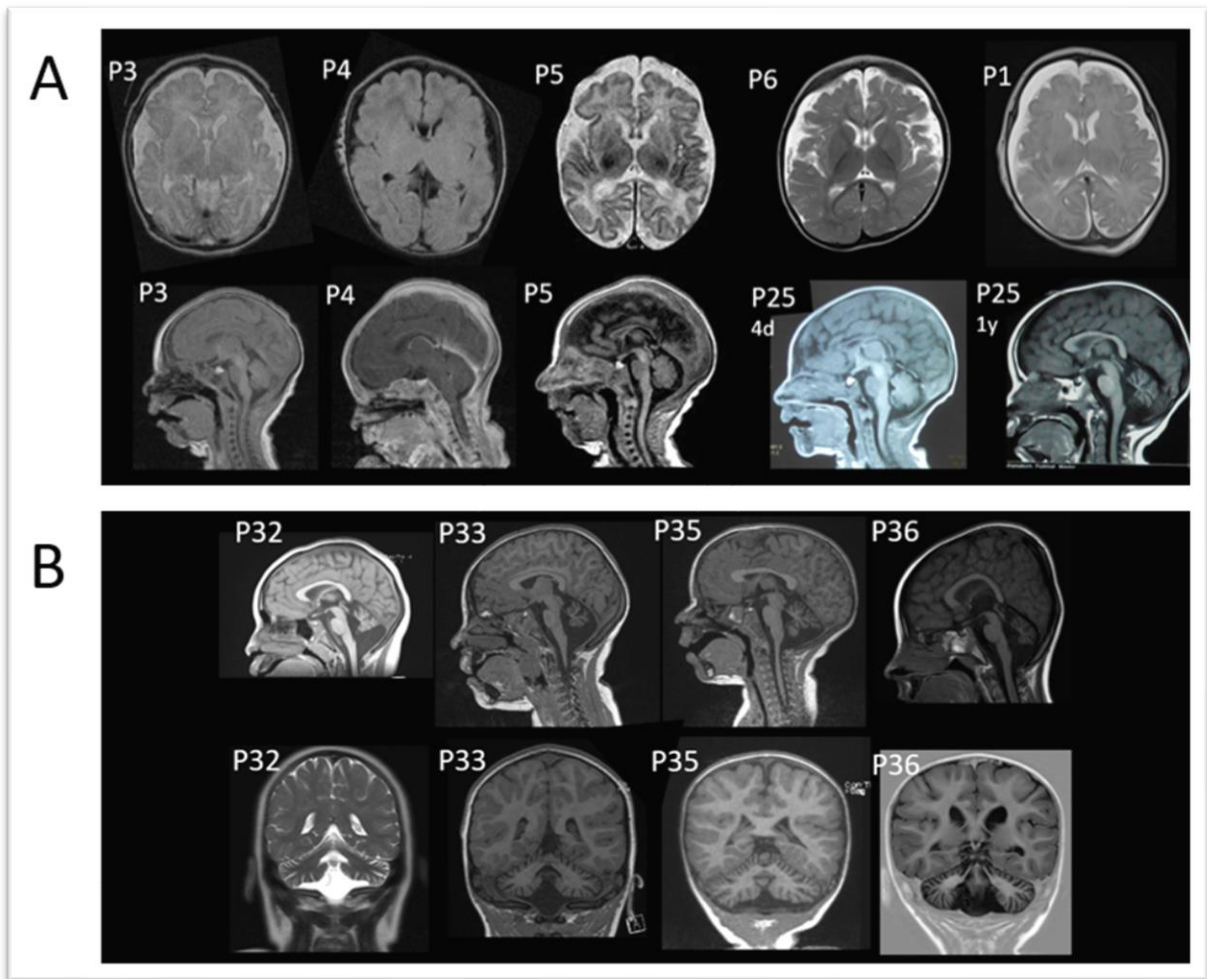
Brain magnetic resonance image (MRI) of individuals with biallelic *BRAT1* variations. A. Cerebral atrophy and enlarged subarachnoid spaces on axial and coronal planes from patients with epileptic encephalopathy (P1, P3, P4, P5, P25). B. Cerebellar atrophy on sagittal and coronal planes from patients with cerebellar ataxia (P32, P33, P35, P36)
